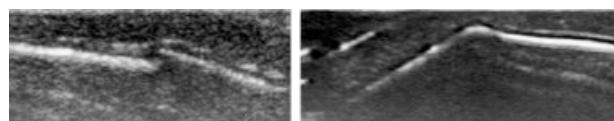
Ultrasound image of overlapping bone edges, a physiological phenomenon observed after birth and in infants with features of plagiocephaly, using a 14 Hz linear probe. B. Ultrasound features of frontal suture craniosynostosis presenting as a ridge-like connection along the cranial sutures, using a 14 Hz linear probe (original material by the author MWM)
